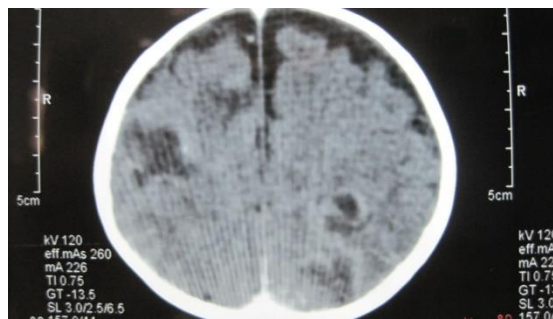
CT Scan showing brain abscess
